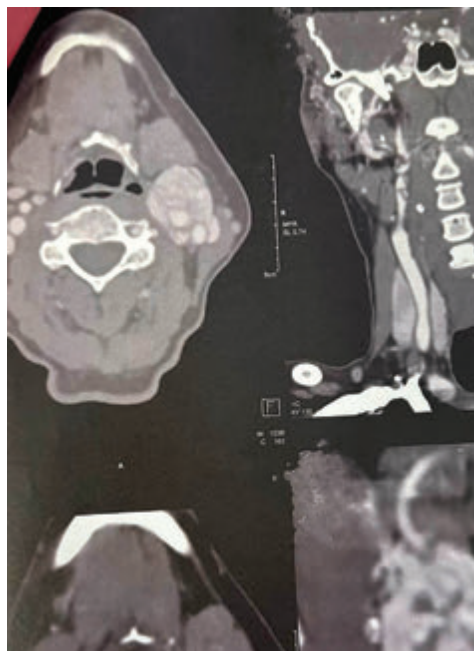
Contrast-enhanced CT scan of the neck demonstrating a well-defined, intensely enhancing hypervascular mass located at the left carotid bifurcation, situated between the external and internal carotid arteries. The lesion measures approximately 32 × 29 × 52 mm and produces characteristic splaying of the carotid vessels (“lyre sign”), consistent with the appearance of a carotid body paraganglioma.
